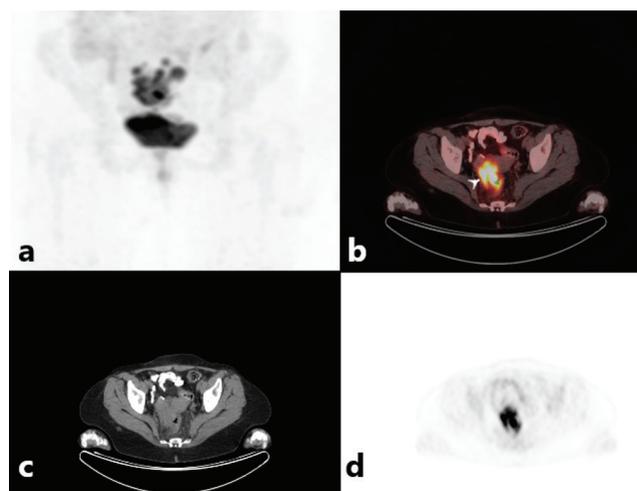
MIP (a), axial fusion, CT and PET (b, c, d) images of a 31-year-old female patient who underwent ^{18}F -FDG PET/CT scanning for breast cancer revealed intense ^{18}F -FDG avid mass (SUV_{max} : 12.7) in sigmoid colon (arrow head) which turned out to be an adenocarcinoma of the colon. CT: Computed tomography, PET: Positron emission tomography, ^{18}F -FDG: ^{18}F Fluorine-fluorodeoxyglucose, SUV_{max} : Maximum standardized uptake value
